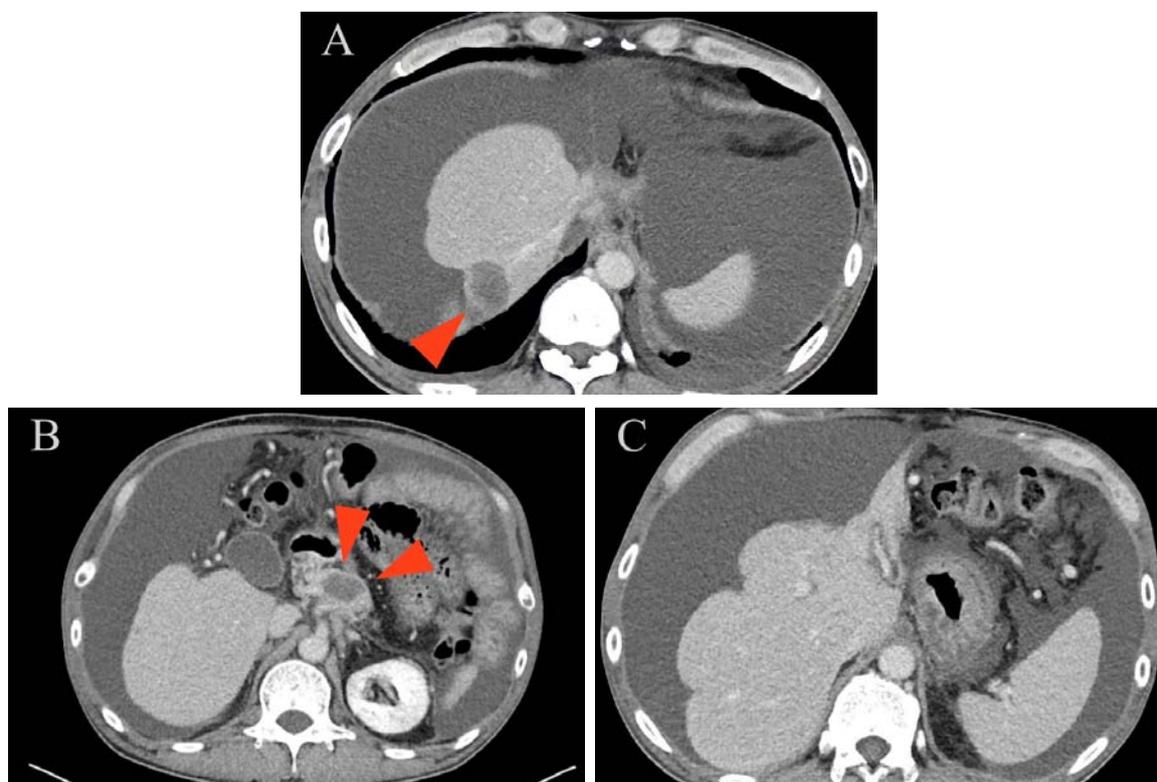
Abdominal CT findings 4 years and 7 months after the start of chemotherapy. A: Recurrence of liver metastasis was seen in S7 region and tended to increase (arrowhead). B: There was also an increase in peripancreatic mesenteric lymph node metastasis (arrowhead). C: Ascites was markedly increased and abdomen was also noticeably distended.
